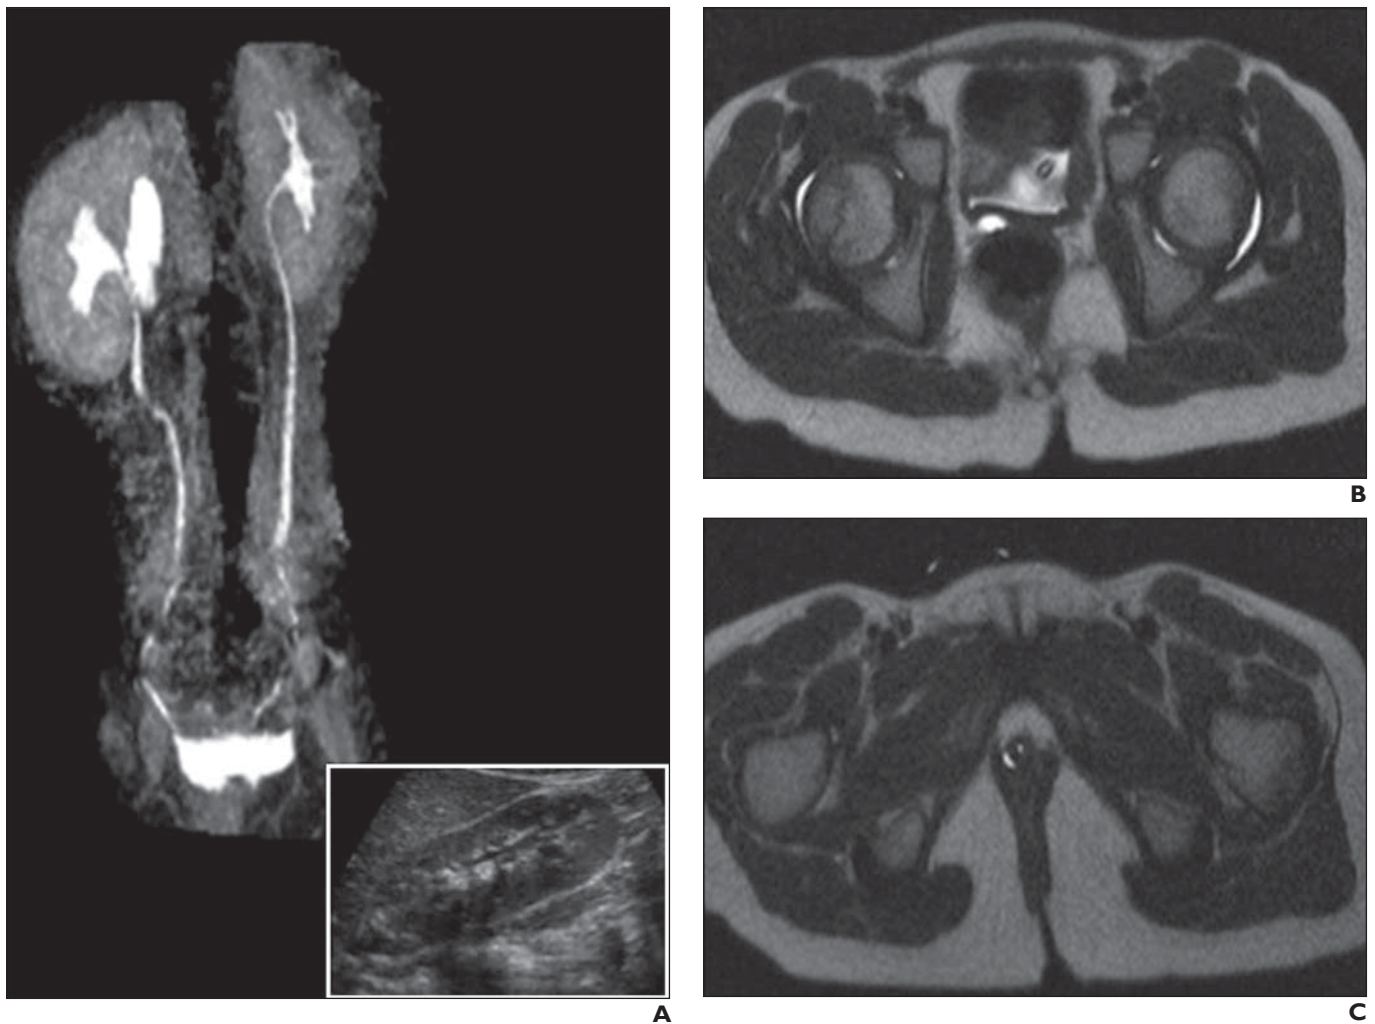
Ectopic ureter in 7-year-old girl with normal ultrasound findings. Most ectopic ureters will present with abnormal ultrasound findings. Ultrasound typically shows hydroureteronephrosis and dilated ureter dropping below bladder neck. (Reprinted with permission from [2]: Lambert SM, Zdreic SA. Chapter 21: embryology of the female urogenital system and clinical applications. In: Cardozo L, Staskin D, eds. *Textbook of female urology and gynecology*, vol. 1. Abingdon, UK: Taylor and Francis, 2009:172–184) A, Ultrasound image of right kidney. Ultrasound image shown in inset depicts normal findings. Because this child was continuously wet but had normal voiding diary and normal urinary flow rate, decision was made to perform MR urography. B and C, MR urographic images show small dysplastic right upper pole segment that drains into hypoplastic ureter; hypoplastic ureter inserts into urethra.
